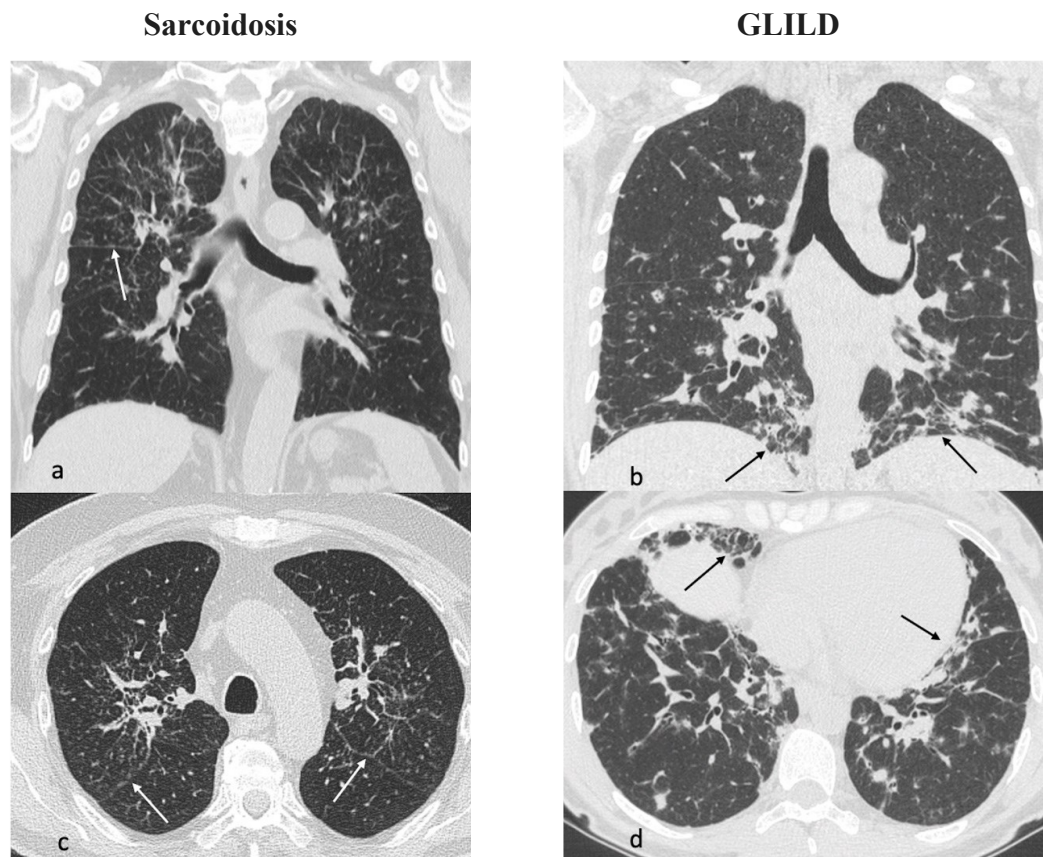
HRCT of our two patients, one with sarcoidosis (a,c) and one with GLILD (b,d). It appears clearly that sarcoidosis has a prevalent medium-upper involvement, with multiple perilymphatic nodules (white arrows) and perihilar fibrosis. On the other hand, GLILD has a lower distribution, with consolidations and nodules; reticulations (black arrows) with some signs of fibrosis can also be seen⁷¹.
